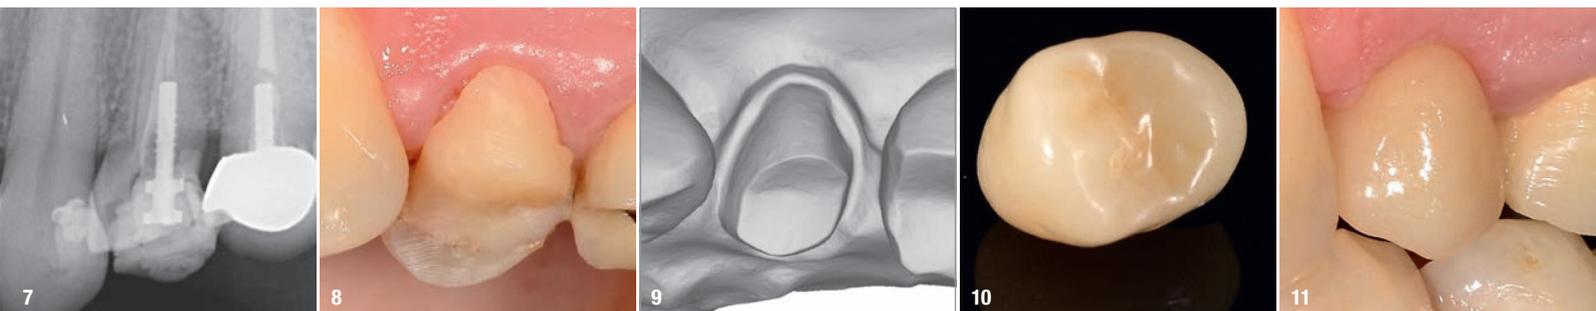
The radiograph shows a subgingival partial fracture of a tooth which had undergone endodontic treatment at one time. Fig. 8: A diode laser can be used to remove excess gingival tissue and thereby bring the fracture margin outside the gingival sulcus. Fig. 9: Correct impression files need to be sent to the dental laboratory. Fig. 10: An all-zirconia crown was fabricated by Laboratoire LDA. Fig. 11: At the two-month follow-up visit, the results appeared stable in terms of the crown fit and gingival healing.
